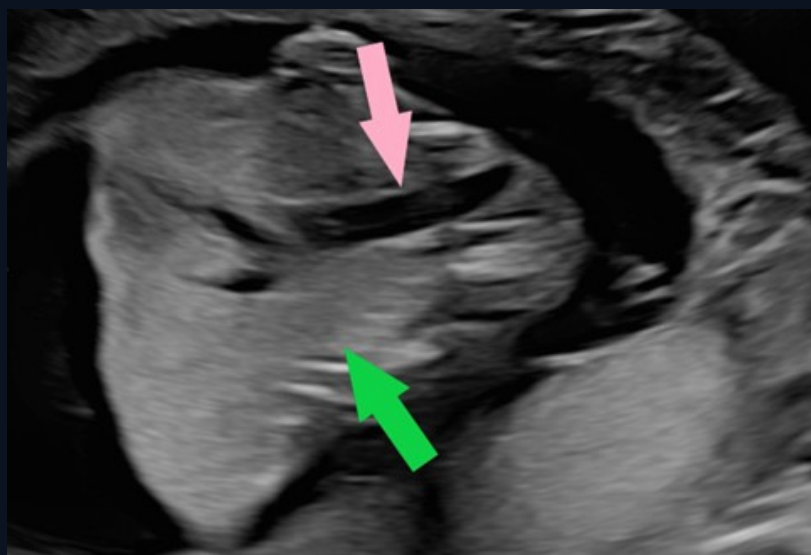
This greyscale ultrasound image in the coronal plane demonstrates an abnormal fluid-filled trachea (pink arrow). The enlarged hyperechoic lungs (green arrow) are again noted.
